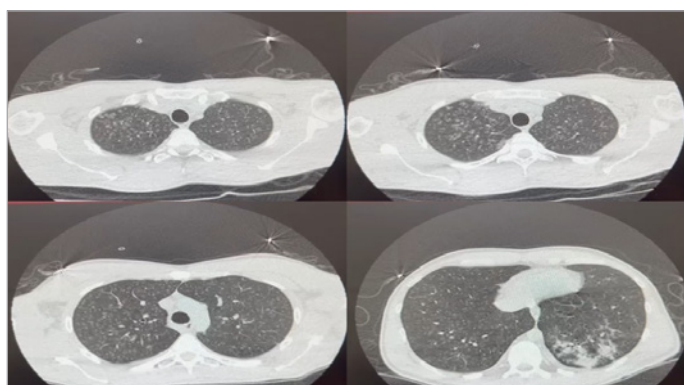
The axial section of the thoracic CT scan for the patient reveals widespread miliary centrilobular infiltrations in both lungs, along with consolidation observed in the lower lobe of the left lung.
